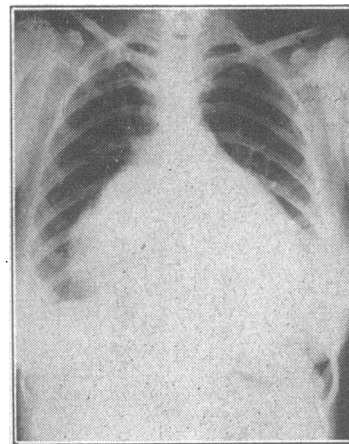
Chest x-ray of patient shown in Fig. 12 taken when myxoedema had developed after a therapeutic total thyroidectomy; great increase in cardiac silhouette due to pericardial effusion.
